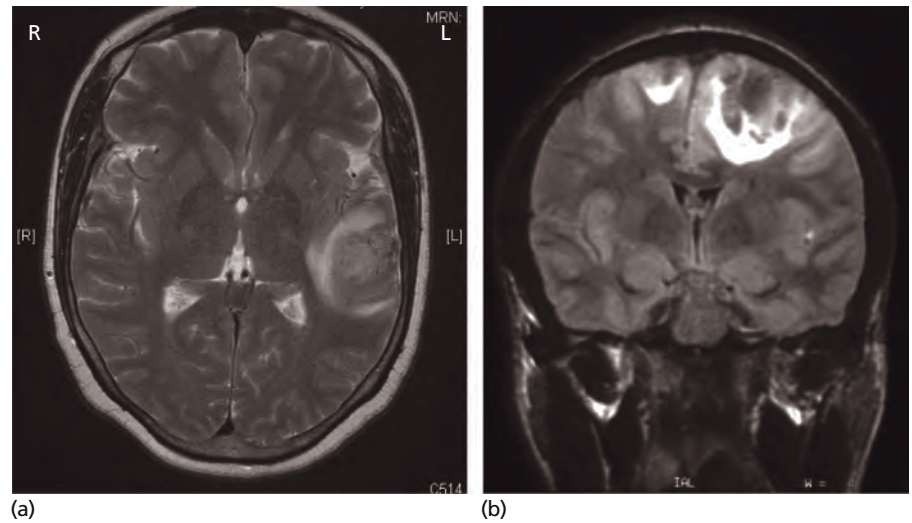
Extensive haemorrhagic cortical venous thrombosis. (a) T2 axial MRI; (b) T1 coronal MRI.
